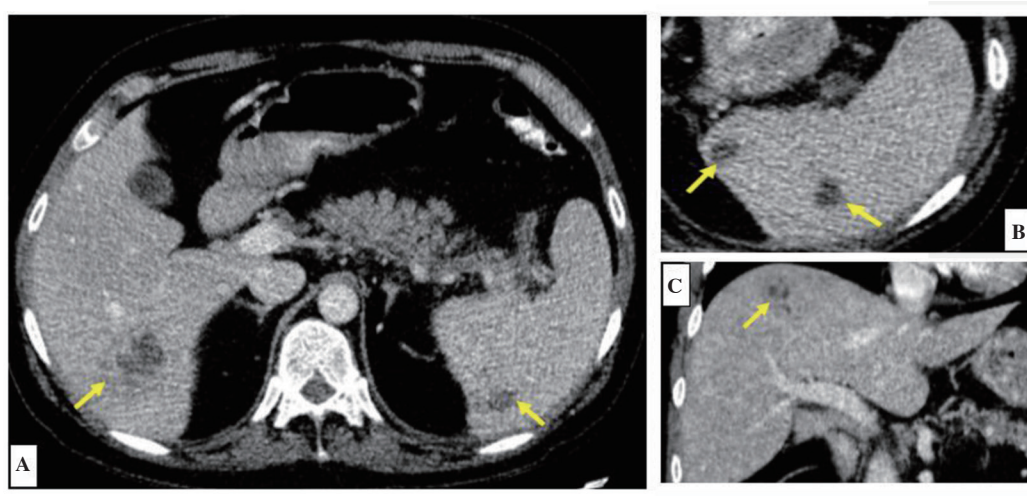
Computed tomography axial (A and B) and coronal (C) sections. Arrows indicate multiple clusters of partially liquefied thick walled abscesses in the liver (largest in segment 6 measures 2.5 to 3.0 cc) and spleen observed in a 34-year-old male presented with a 15-day history of fever 4 years after kidney transplantation.
